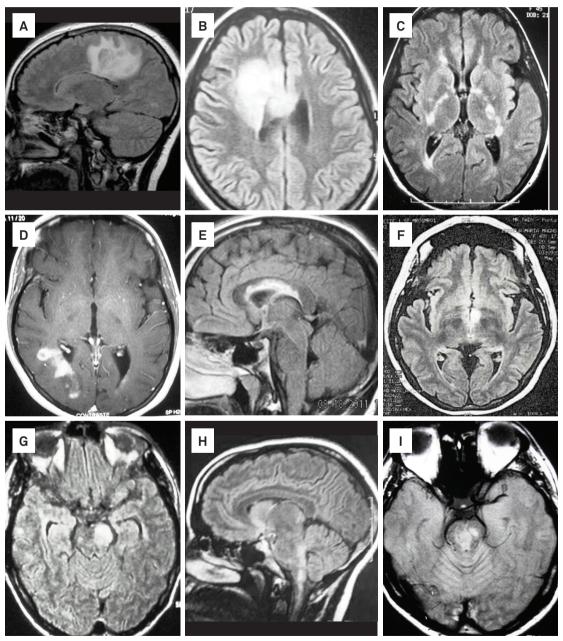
Typical brain magnetic resonance imaging in neuromyelitis optica. (A) Extensive edematous white matter lesion. (B) Tumefactive frontal lobe lesion. (C) Bilateral lesions in the posterior limb of the internal capsule. (D) Cloud-like gadolinium-enhanced lesion. (E) Heterogeneous extensive callosal lesion. (F) Bilateral lesions in the hypothalamus. (G) Large mesencephalic lesion. (H) Lesion involving area postrema. (I) Central brainstem lesion.
